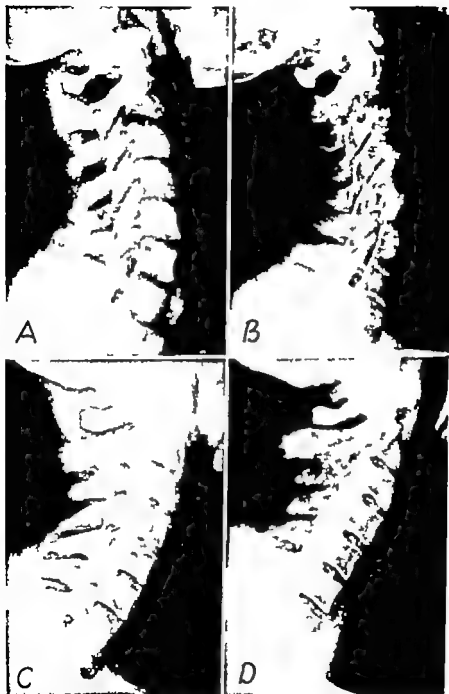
Radiographs of two cervical spines, (A) and (C) which were made with the necks in hyperextension and which show overriding of the spinous processes of the fourth, fifth and sixth vertebrae. Films (B) and (D) were made with the necks in hyperextension a few weeks following removal of the spinous processes. (O'Donoghue's cases.)
